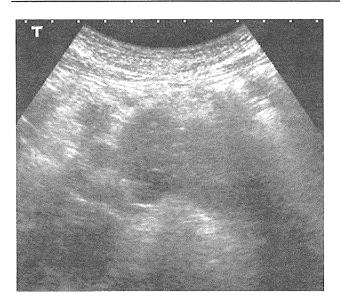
Abdominal ultrasonography in AIP (diffuse type). A diffusely enlarged pancreas appears as a low echo area with high echoic spots and has a so-called "sausage-like" appearance
